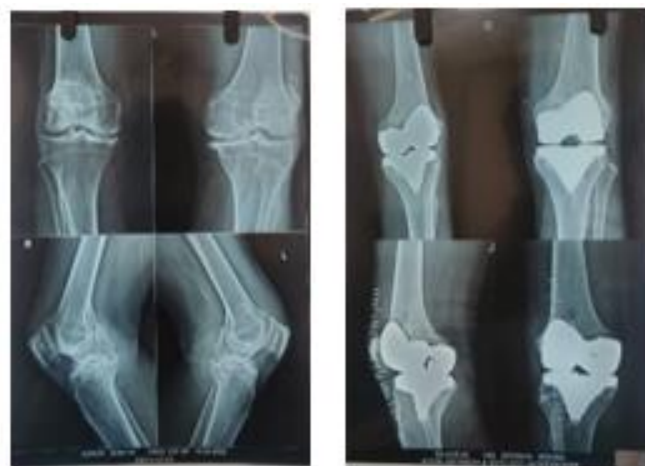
Pre and Post Operative X-rays
